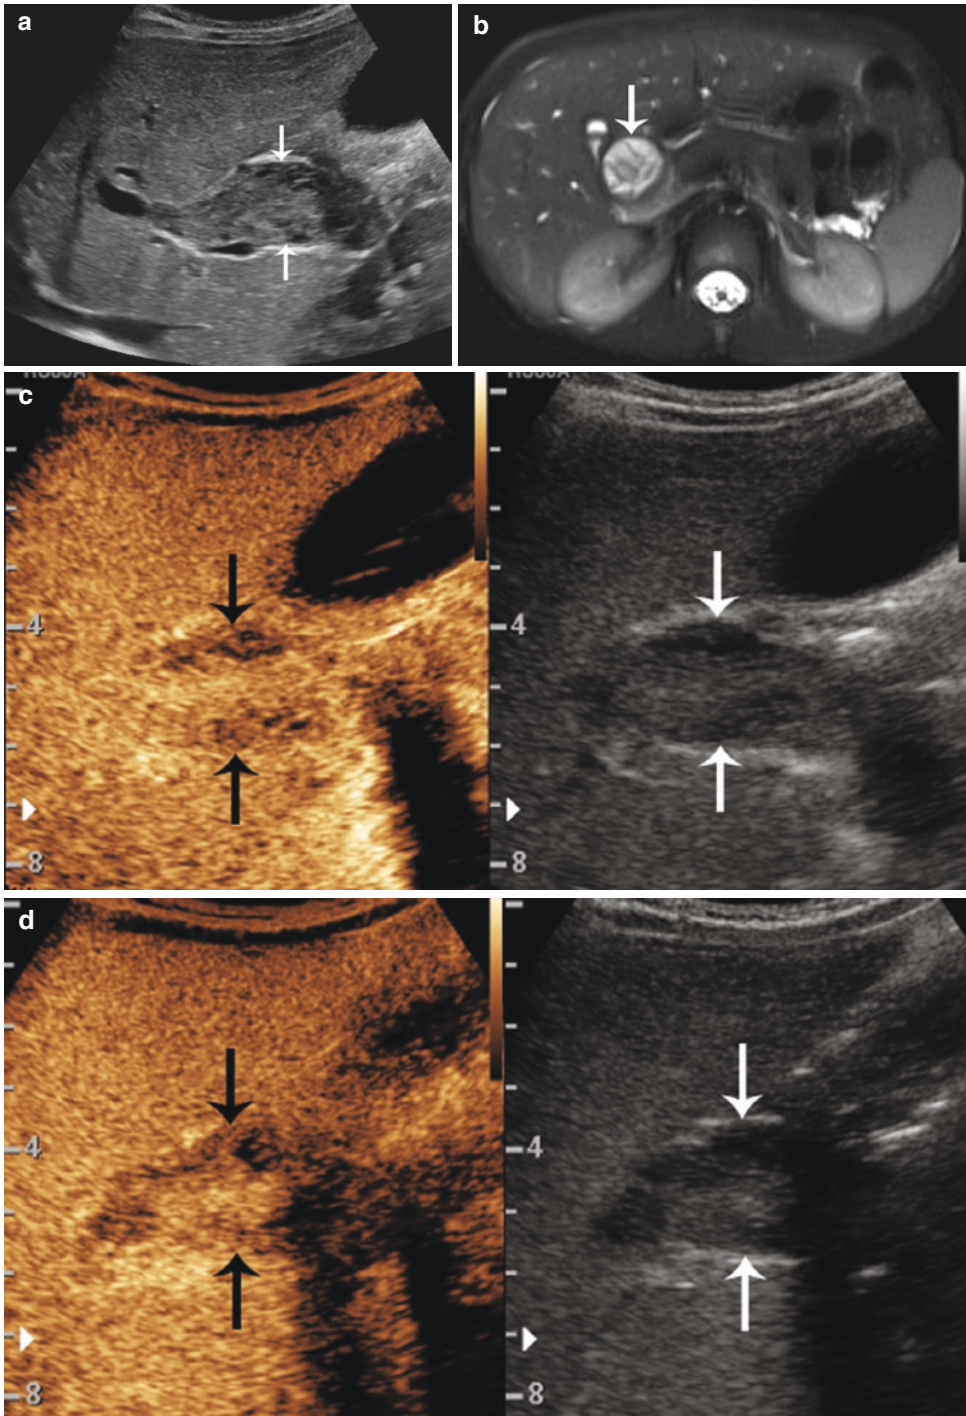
A 5-year-old boy with rhabdomyosarcoma of the biliary tree. (a) Transverse grayscale ultrasound image shows tumor arising from the common bile duct (arrows). Transverse CEUS images (left side of panels) show (b)
